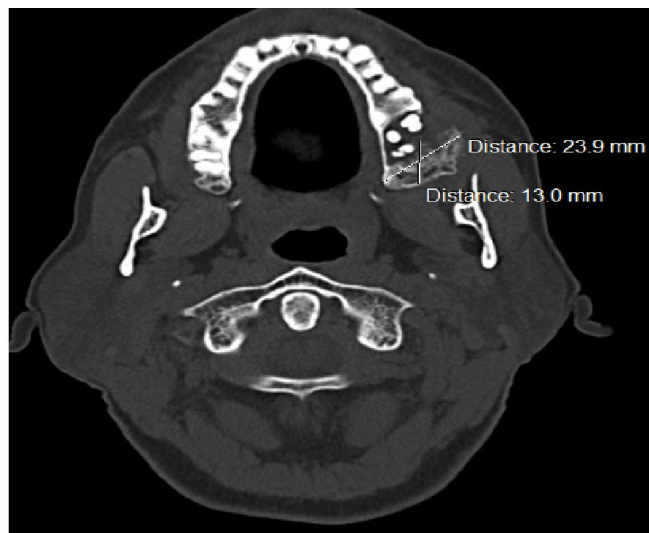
CT scan shows mixed lesion involving the left posterior maxilla showing a ground glass pattern
